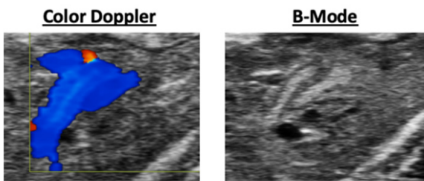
Color Doppler and B-Mode scans of pulmonary artery velocity.
